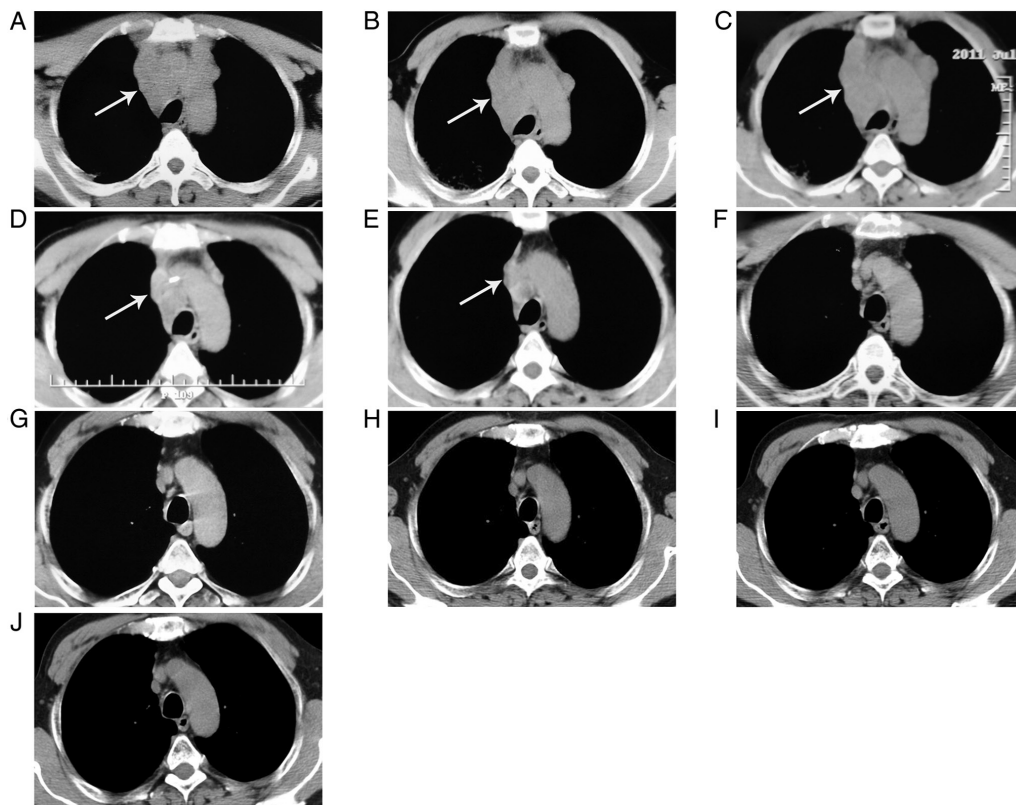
Changes of the enlarged lymph nodes over time by chest computed tomography scan of the mediastinum. (A) Before any treatment (2011-5-16). (B) After anti-inflammatory treatment (2011-6-3). (C) During therapy of docetaxel + carboplatin (2011-7-9). (D) During therapy of gemcitabine + cisplatin (2011-9-19). (E) During therapy of gemcitabine + cisplatin (2011-11-30). (F) After therapy of gemcitabine + cisplatin + radiation (2012-10-8). (G) Review (2014-4-11). (H) Review (2016-8-18). (I) Review (2018-7-3). (J) Review (2020-2-10). Arrows indicate enlarged lymph nodes.
